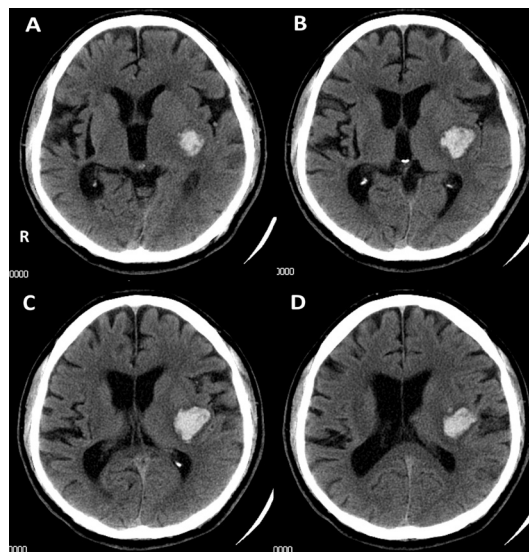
Brain CT image on admission. There was fresh haemorrhage in the left putamen. The bleeding expanded over the putamen slight posteriorly and laterally, but it did not apparently involve the transverse temporal or superior temporal gyri (A–D). An old haemorrhage in the right putamen was also apparent (A–C).
